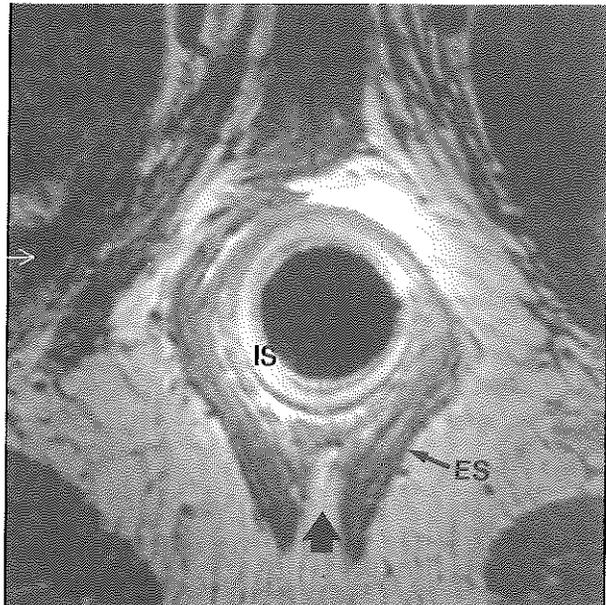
Endoanal MRI, axial proton density weighted GRE showing posterior a discontinuity of the external sphincter (ES) ring (arrow). This can be interpreted as a defect but is in fact a normal variant determined by the anococcygeal ligament. On higher scans, the external sphincter fibers will merge posterior reestablishing the common shape. Internal sphincter (IS).
